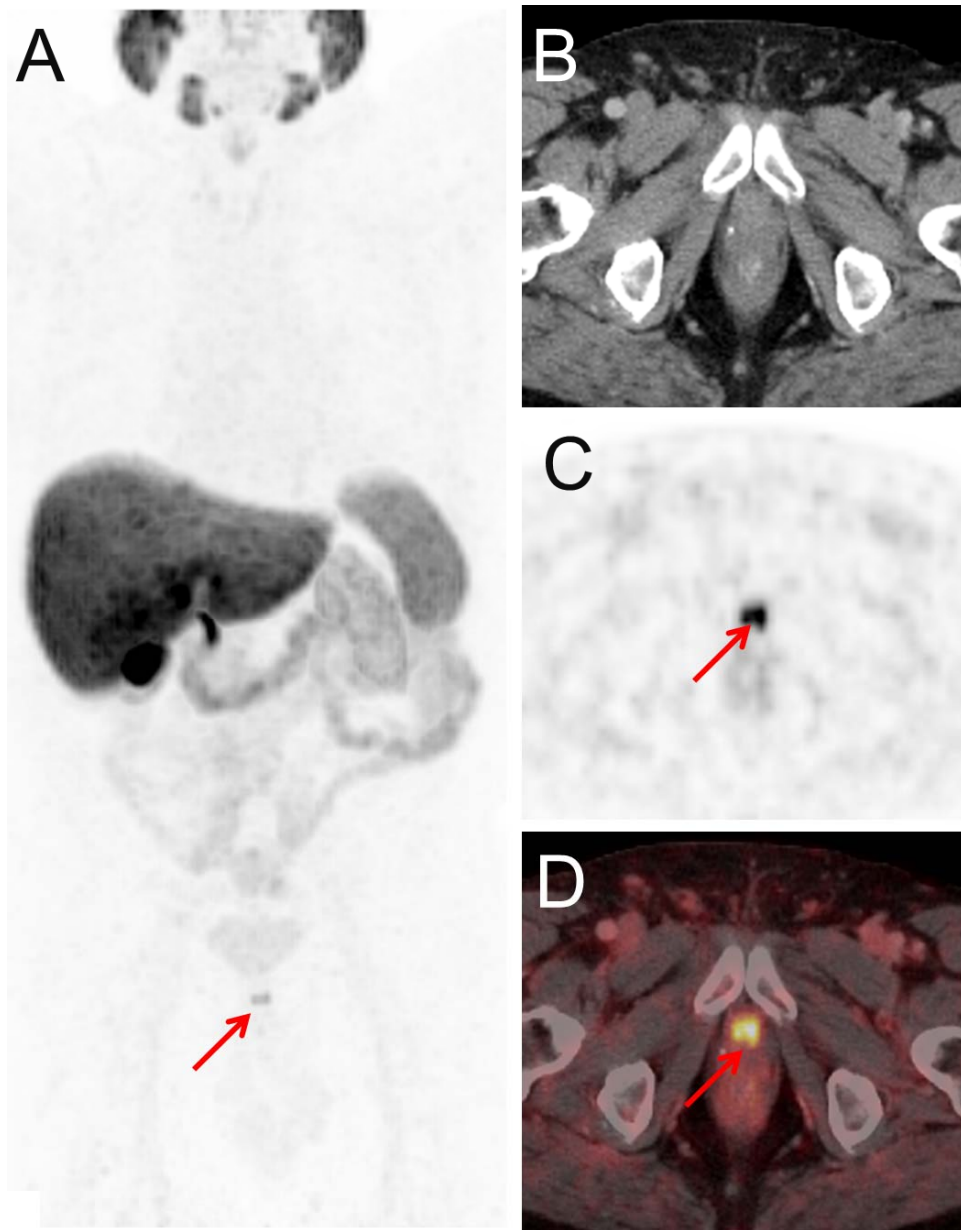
Set of images of a 64 year old patient with status post radical prostatectomy (08/2012, Gleason Score 9, pT3b, pN0) and rising PSA-value of 3.9 ng/mL (10/2017). Maximum-intensity projection of [¹⁸F]PSMA-1007 PET shows an intense tracer-associated uptake in a lesion below the bladder (A). It can be localized in the region of the urethral anastomosis using transaxial PET (C) and fused PET/CT images (D). Post-imaging salvage radiation to the prostatic fossa was performed combined with a single injection of a GnRH-analog in 10/2017 resulting in a drop of PSA-value below detection threshold (<0.07 ng/ml, last measurement 02/2018).
